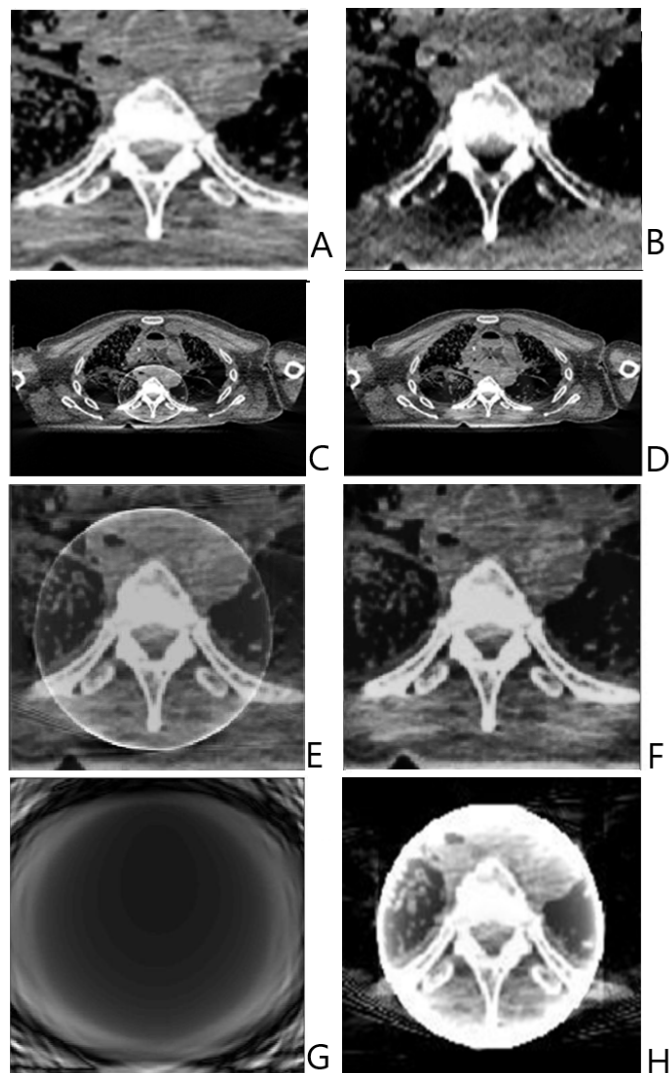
Results from use of the FCT method to produce an ROI over the thoracic spine, showing A) a magnified view of the original CT scan using 17 mGy, B) a magnified view of the original CT scan using 1.7 mGy, C) the complete reconstruction using FCT1, D) the complete reconstruction using FCT2, E) a magnified view of the ROI using FCT1, and F) a magnified view of the ROI using FCT2, G) the difference image between the original high-dose and FCT1 reconstructions of the ROI, and H) a reconstruction of an ROI using only local data, for comparison purposes. Notice that A and F are essentially identical in the interior.
